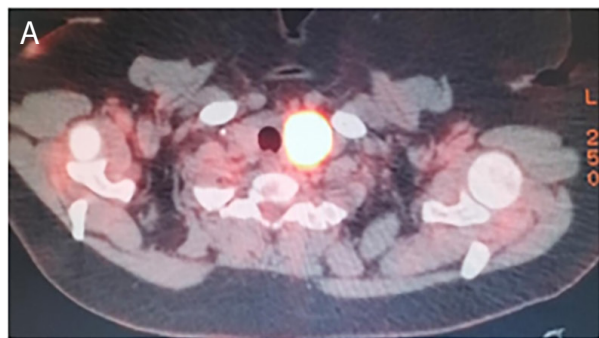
A-B Thyroid and lung metastasis at PET/CT imaging.
